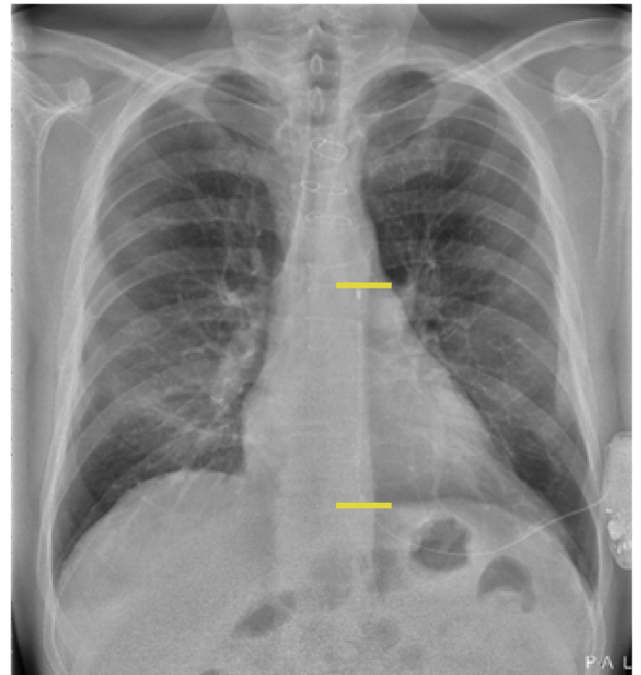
Anteroposterior view of the postimplant chest radiograph. The inferior position of the proximal lead causes a higher risk of stimulating the diaphragm or abdominal musculature, instead of the critical mass of the heart.
